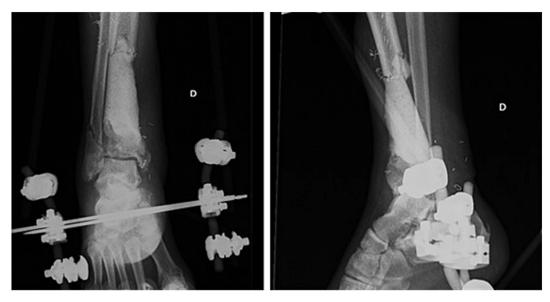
Radiographs performed two days after the patient was admitted to hospital showing the new cement spacer in place.
